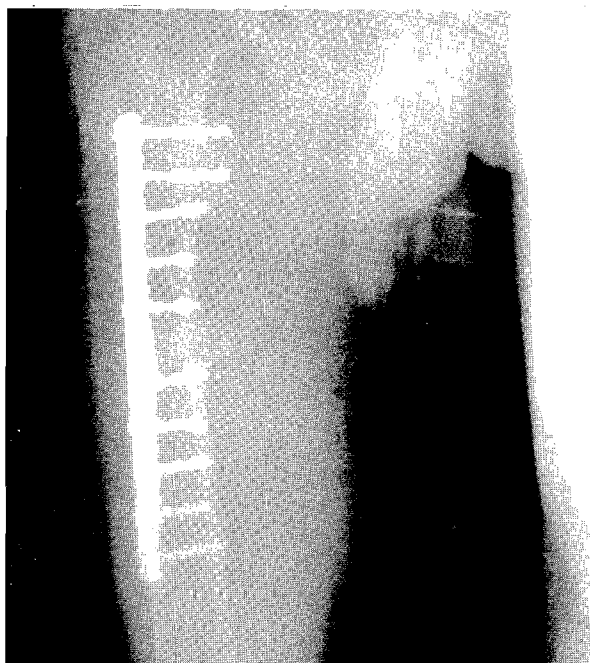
A photo-radiograph (AP view) of the same limb after open reduction and internal fixation with plates and screws (preceded by four weeks of continuous skin traction).
